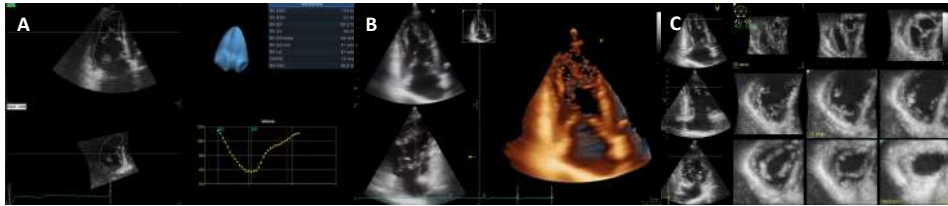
Three-dimensional transthoracic echocardiography of the right ventricle. (A) By tracing the endocardial RV borders (top and bottom left), a 3D volume of the RV (top right) is obtained throughout the cardiac cycle (bottom right) and 3D RVEF is calculated. Note the RV inflow and outflow tract in the 3D model. (B) Real-time single-beat 3D acquisition of the RV from the dedicated apical window. (C) Tomographic multislice obtained from a multiple-beat apical view.
